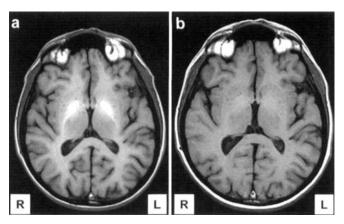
Typical MRI brain scan of a patient with cirrhosis and minimal HE showing pallidal hyperintensity (a), with complete resolution 4 months after successful OLT (b)
